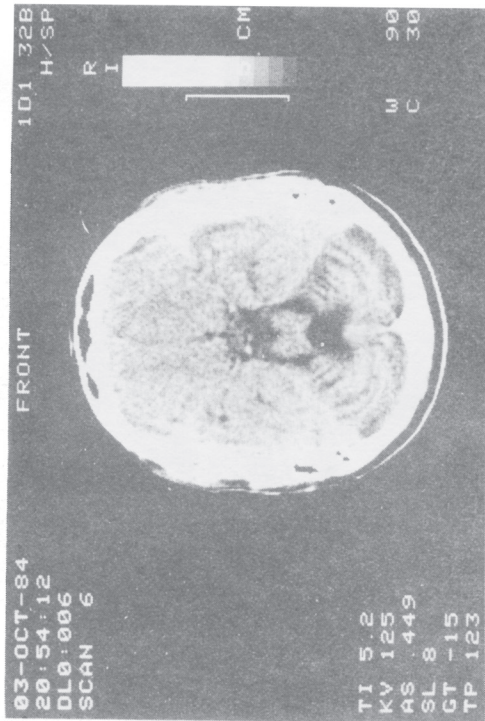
Axial CT section through upper pons revealing widened cerebellar folia from cerebellar atrophy, enlarged fourth ventricle, and atrophy of the brachium conjunctivum and lateral surface of the pons (causing a "molar tooth" effect) seen in this disease.
